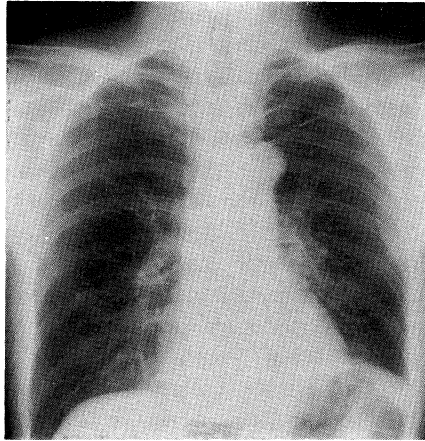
Chest x-ray film taken on admission. Note the widening of the mediastinum on the left side.
